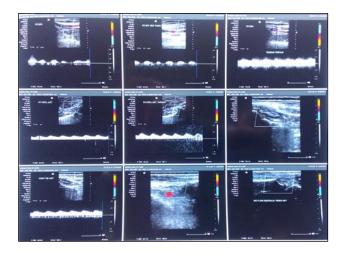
Doppler study of lower limbs arterial system.
